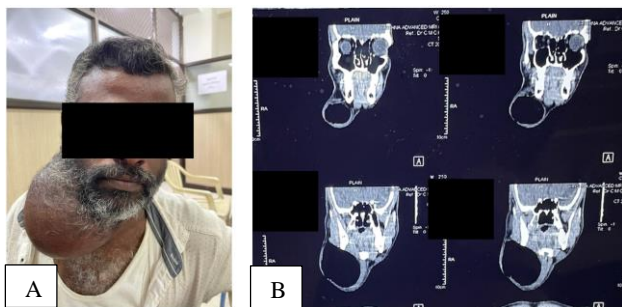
(A and B): Large neck swelling. CT neck revealed this swelling as air pocket from tracheal rent.
